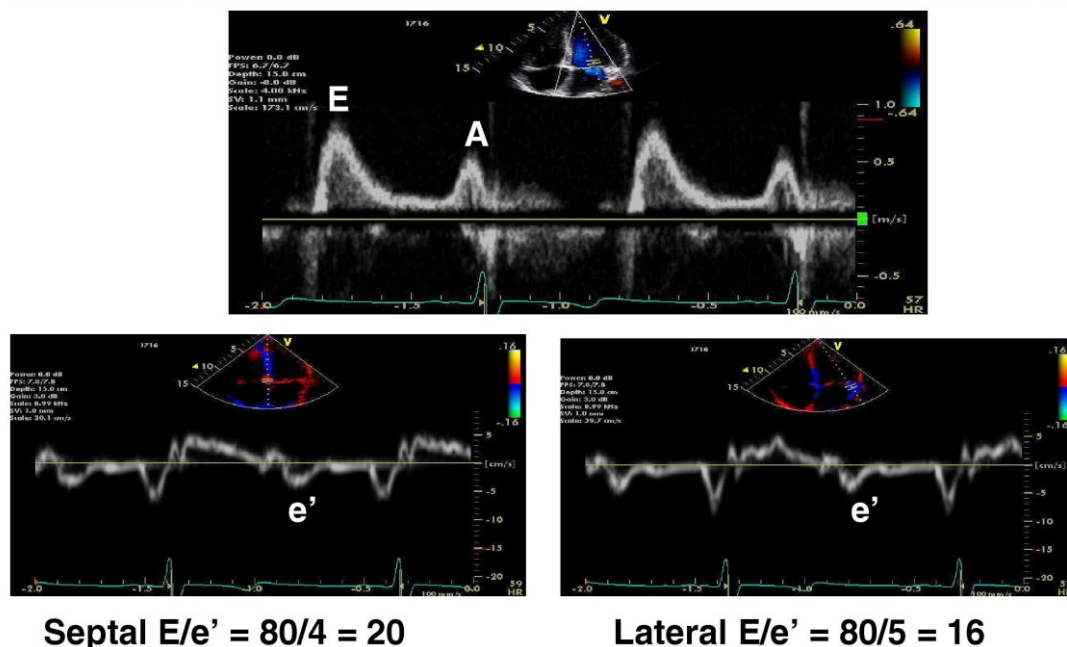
Reproduced from (123) with permission of Elsevier Mitral inflow (top), septal (bottom left), and lateral (bottom right) tissue Doppler signals from a 60-year-old patient
